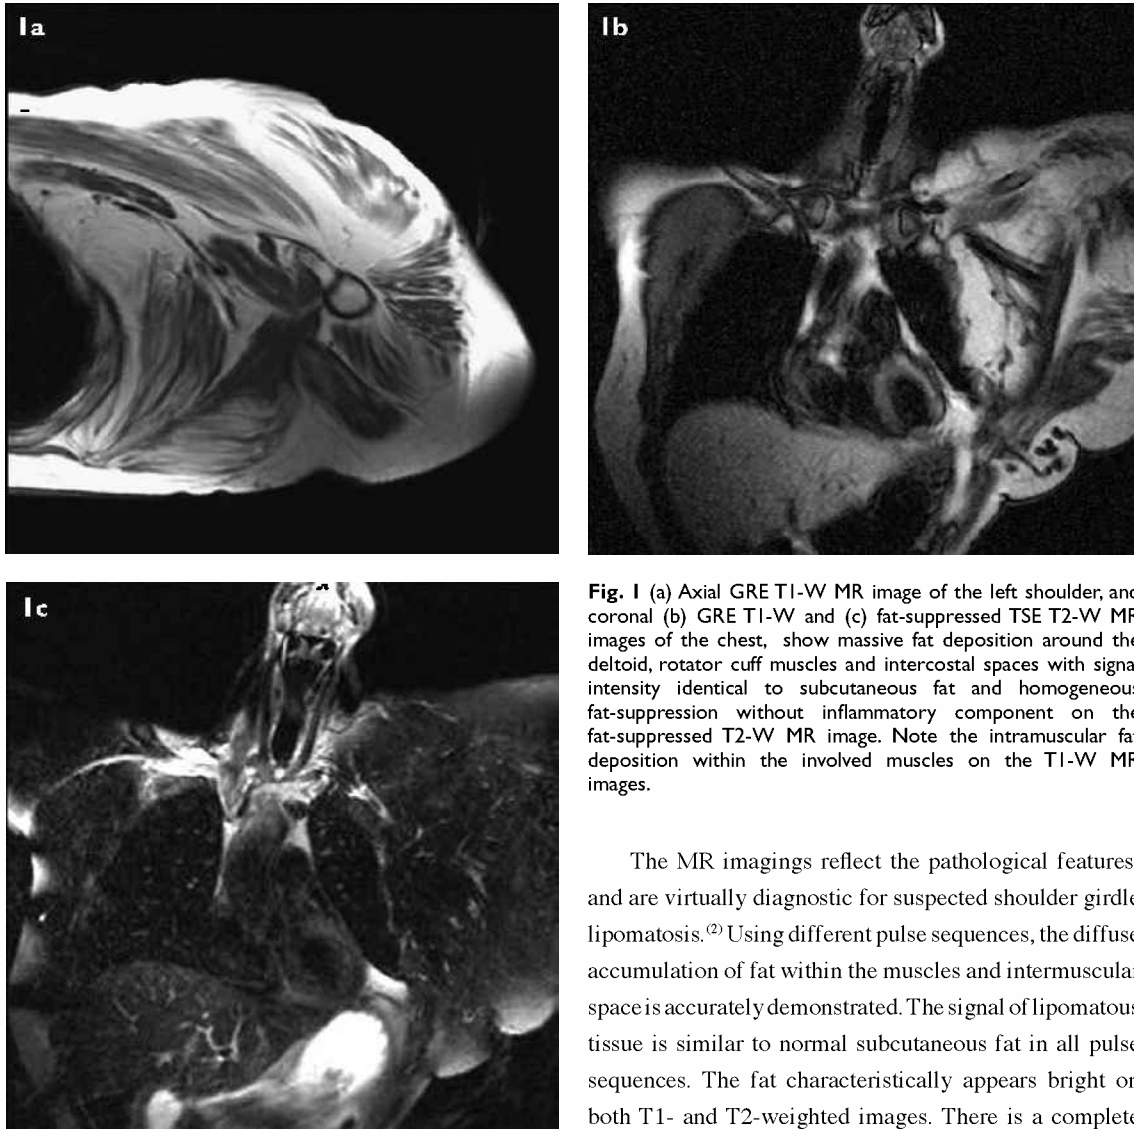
(a) Axial GRE T1-W MR image of the left shoulder, and coronal (b) GRE T1-W and (c) fat-suppressed TSE T2-W MR images of the chest, show massive fat deposition around the deltoid, rotator cuff muscles and intercostal spaces with signal intensity identical to subcutaneous fat and homogeneous fat-suppression without inflammatory component on the fat-suppressed T2-W MR image. Note the intramuscular fat deposition within the involved muscles on the T1-W MR images.
